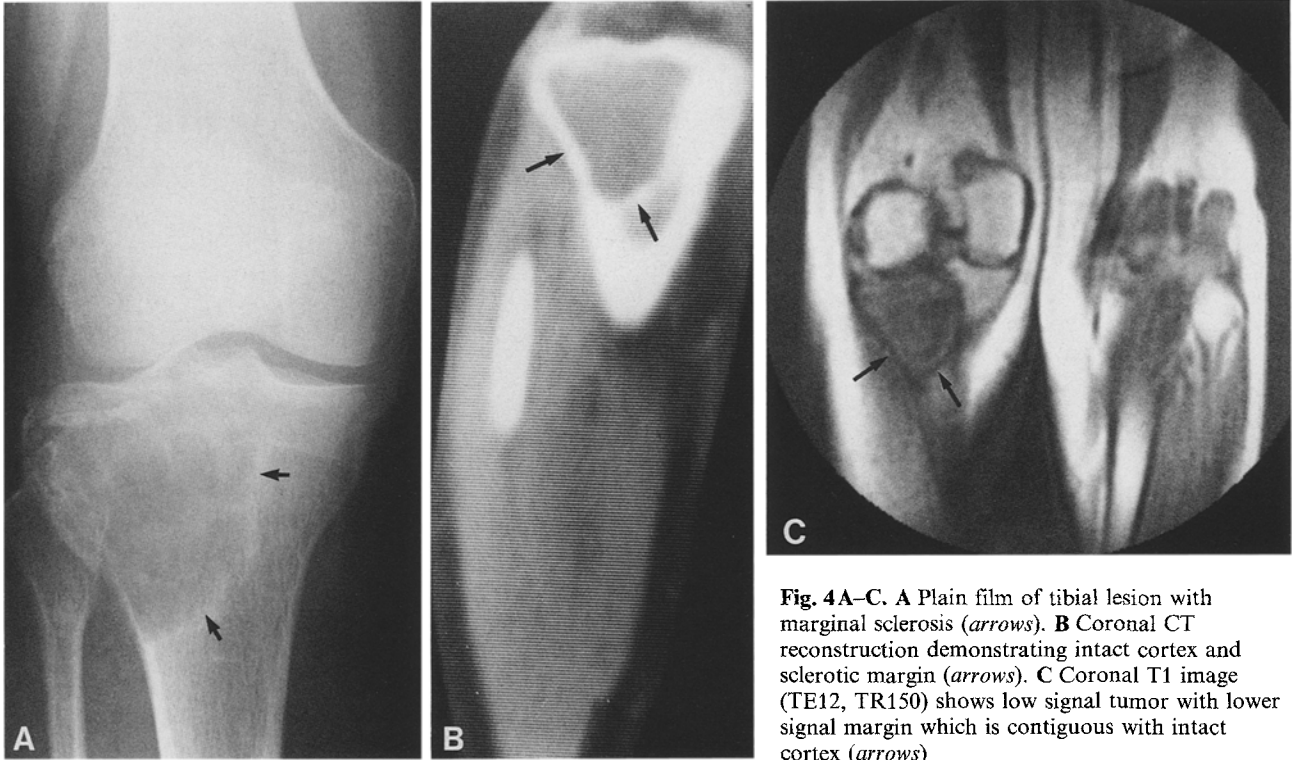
A Plain film of tibial lesion with marginal sclerosis (*arrows*). B Coronal CT reconstruction demonstrating intact cortex and sclerotic margin (*arrows*). C Coronal T1 image (TE12, TR150) shows low signal tumor with lower signal margin which is contiguous with intact cortex (*arrows*)
